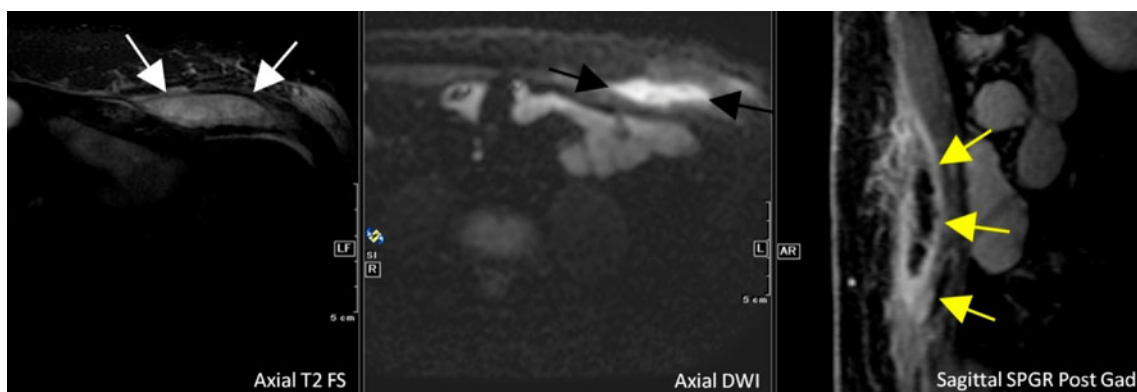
(Case 7): Axial FSE T2 FS MR image showing a heterogeneously hyperintense mass-like lesion (*white arrows*) within the left external oblique muscle. DWI image shows the lesion to be markedly bright (*black arrows*), and this was hypointense on the ADC
